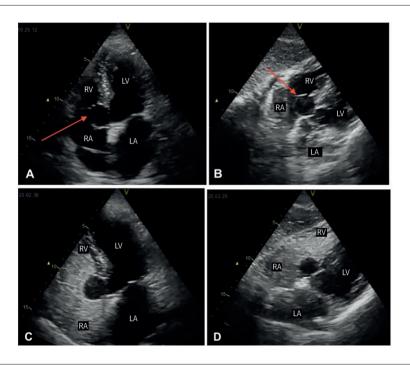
Echocardiogram showing, in a 4-chamber apical window (A) and subcostal (B), anechoic, cyst-like structure in the inner portion of the right atrium, attached to the interatrial septum and adjacent to the tricuspid septal leaflet (red arrows). After peripheral injection of the stirred saline solution, a more precise design of the lesion was observed, with no filling of this by the solution (C and D). LA: left atrium; RA: right atrium; LV: left ventricle; RV: right ventricle. Source: Drafted by the author.
